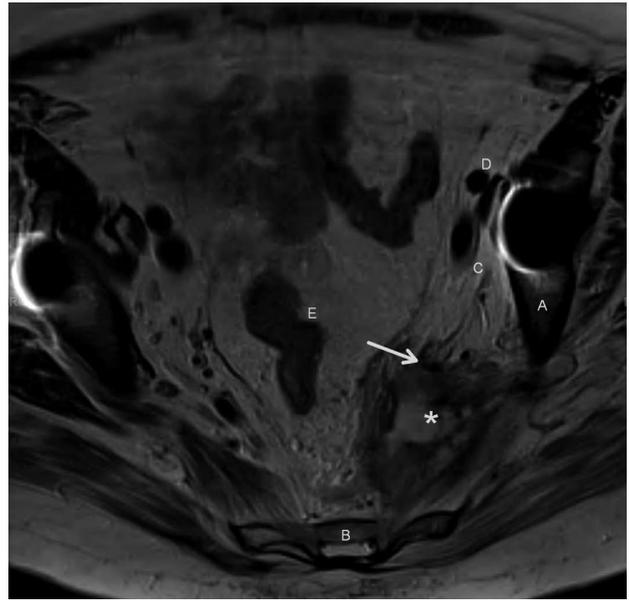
Axial T2-weighted image of pelvic MRI shows involvement of the internal iliac artery (arrow). The vessels appear black secondary to flow void. \* = mass; A = iliac bone (with surgical hardware); B = sacrum; C = external iliac vein; D = external iliac artery; E = colon; arrow = branch of internal iliac artery involved by mass.
